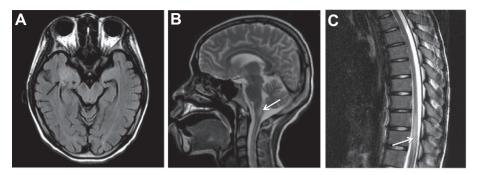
Magnetic resonance imaging of patient 2 showed multiple hyperintensity (arrows) over (A) right mesial temporal area (FLAIR) (B) brain stem (T2-weighted) and (C) thoracic spinal cord (T2-weighted).
